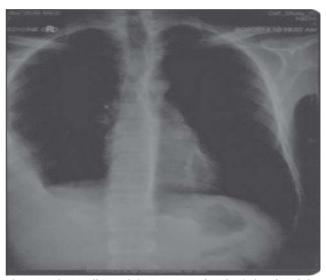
Chest radiograph (postero-anterior view) showing rightsided pleural effusion.
